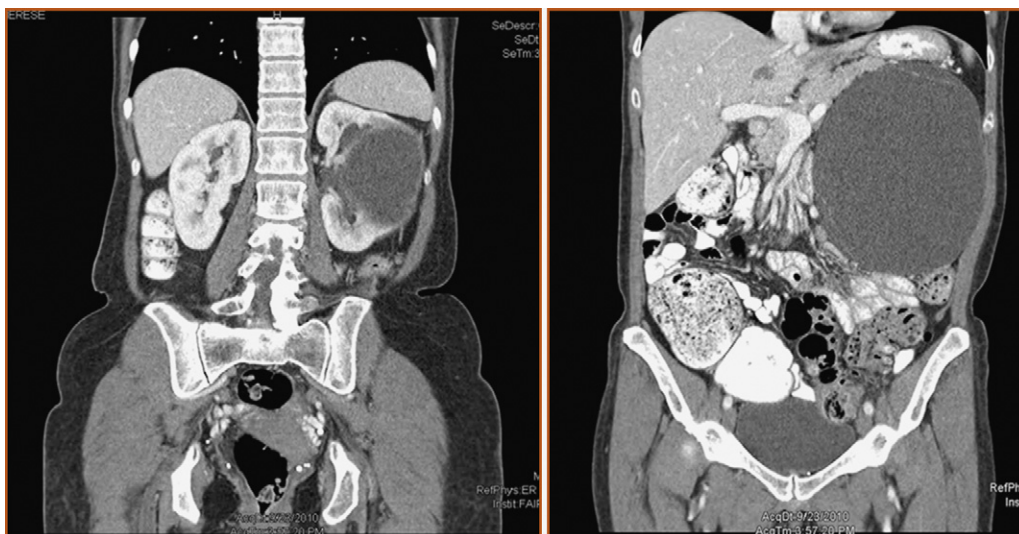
Computed tomography scan showing a Bosniak II left renal cyst measuring 12.4 × 13.1 × 15 cm.
